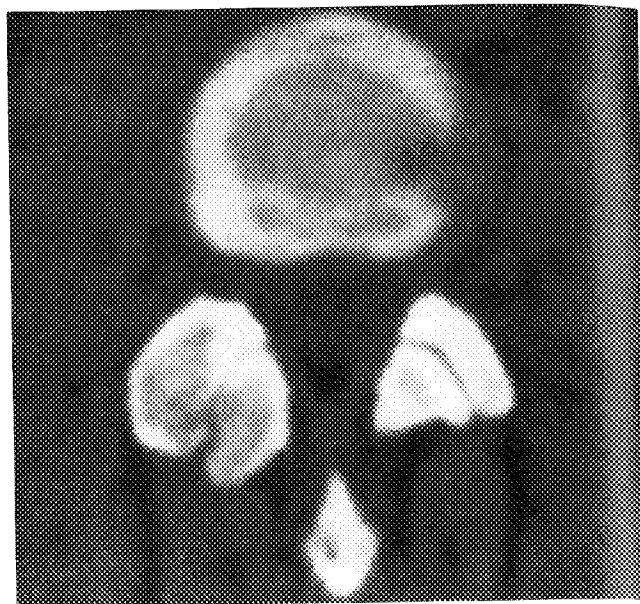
Polyostotic fibrous dysplasia of the adjacent articular facets of L3 and L4 (38-year-old woman). No other part of the skeleton was involved. Computed tomography scan at L3-L4 level shows the expansion of the right facets of L3 and L4 with bony erosion on both sides of the facet joint. Density is homogenous, and the characteristic ground glass appearance is seen.
